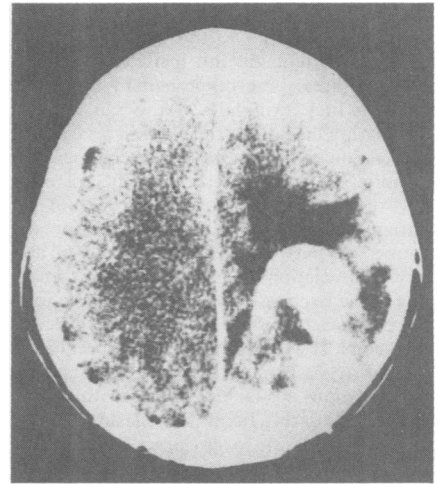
Figure Enhanced CT. A circular high density lesion is situated in the right parieto-occipital area.
